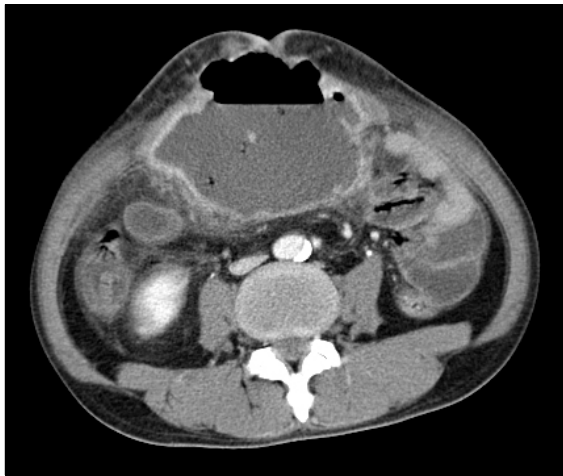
Computed tomography showed huge abscess containing fluid and gas below umbilicus.
